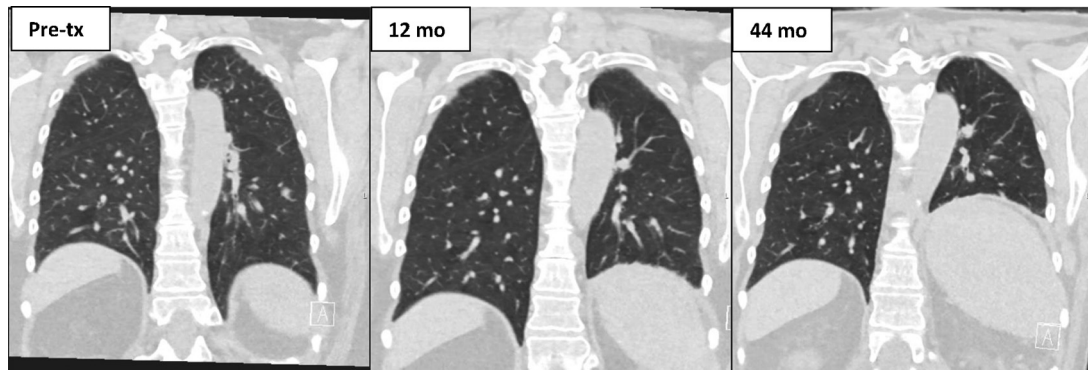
Coronal views of serial CT chest of patient described in case 2 revealing progressive elevation of left hemidiaphragm after SABR (middle and right panels) compared with pre-tx (left panel). CT, computed tomography; mo, months post-treatment; SABR, stereotactic ablative radiotherapy; tx, treatment.
